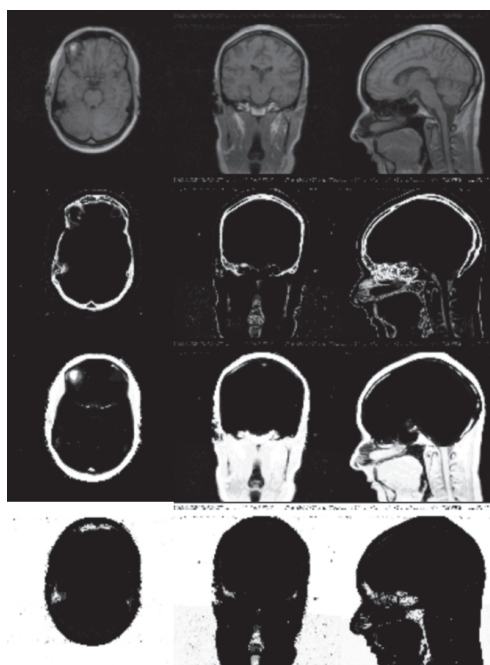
Anatomical MR image used for segmentation (top 1st row) with the non-processed tissue probability maps for bone (2nd row), scalp (3rd row) and air (4th row) from the New Segment function of SPM8. The tissue classes are well-separable. Modified from Study II. © 2016 IEEE
